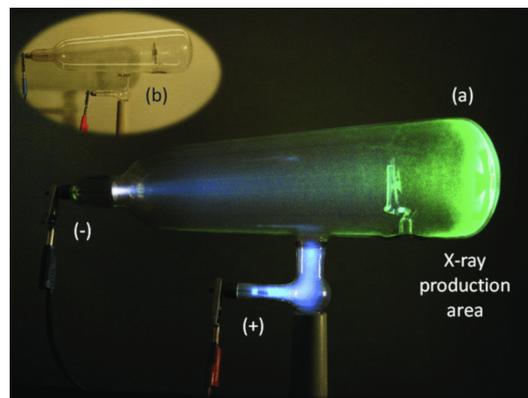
Picture of a Crookes Tube, which can be used to accelerate electrons and create x-rays
